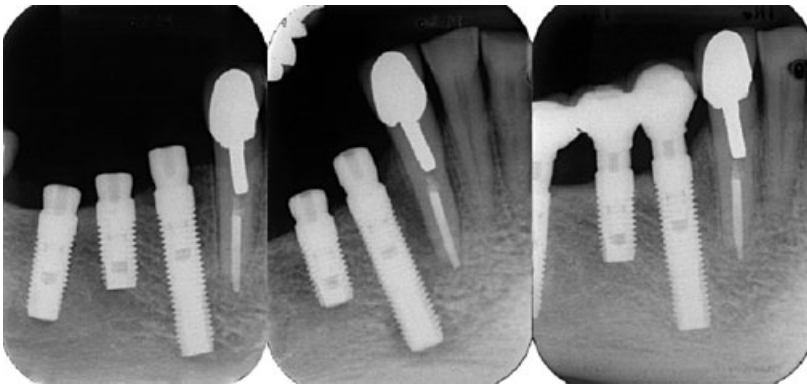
Soon after implant insertion the patient presented with slight pain. A radiograph (left image) was interpreted as showing normal conditions. Two weeks later the pain had increased in intensity and a radiolucency could now be seen around the tip of the most mesial implant (middle image). The right image, taken some months later shows completely normal conditions.
